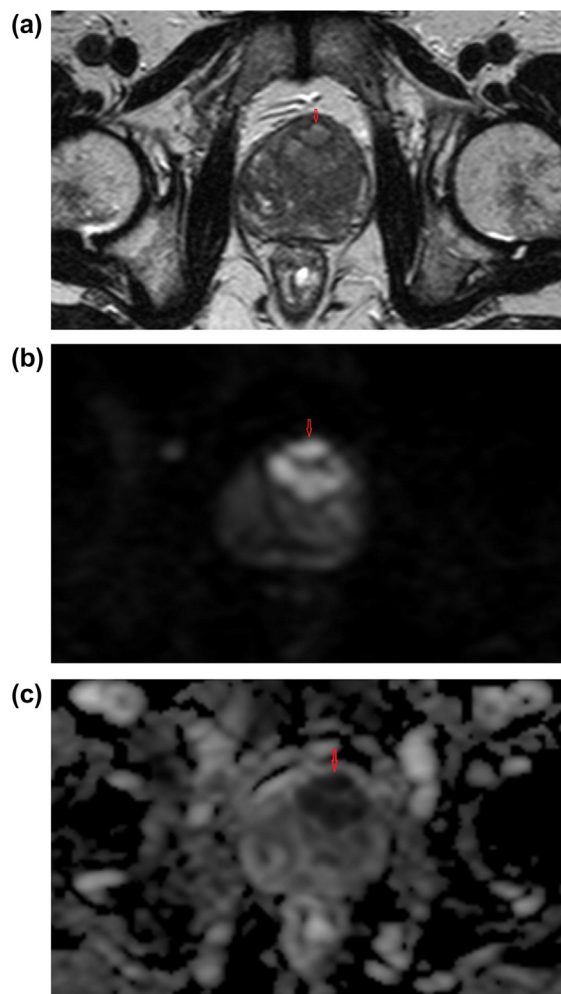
Prostate cancer: axial T2WI (a) shows ill-defined hypointense focal lesion at central prostatic zone, more to the left side (arrow). It displays hyperintense signal at DWI (b = 1000) (arrow) (b) and low-signal intensity (arrow) at ADC map (c). ADC = 0.67×10^{-3} mm²/sec and nADC of 0.33.
